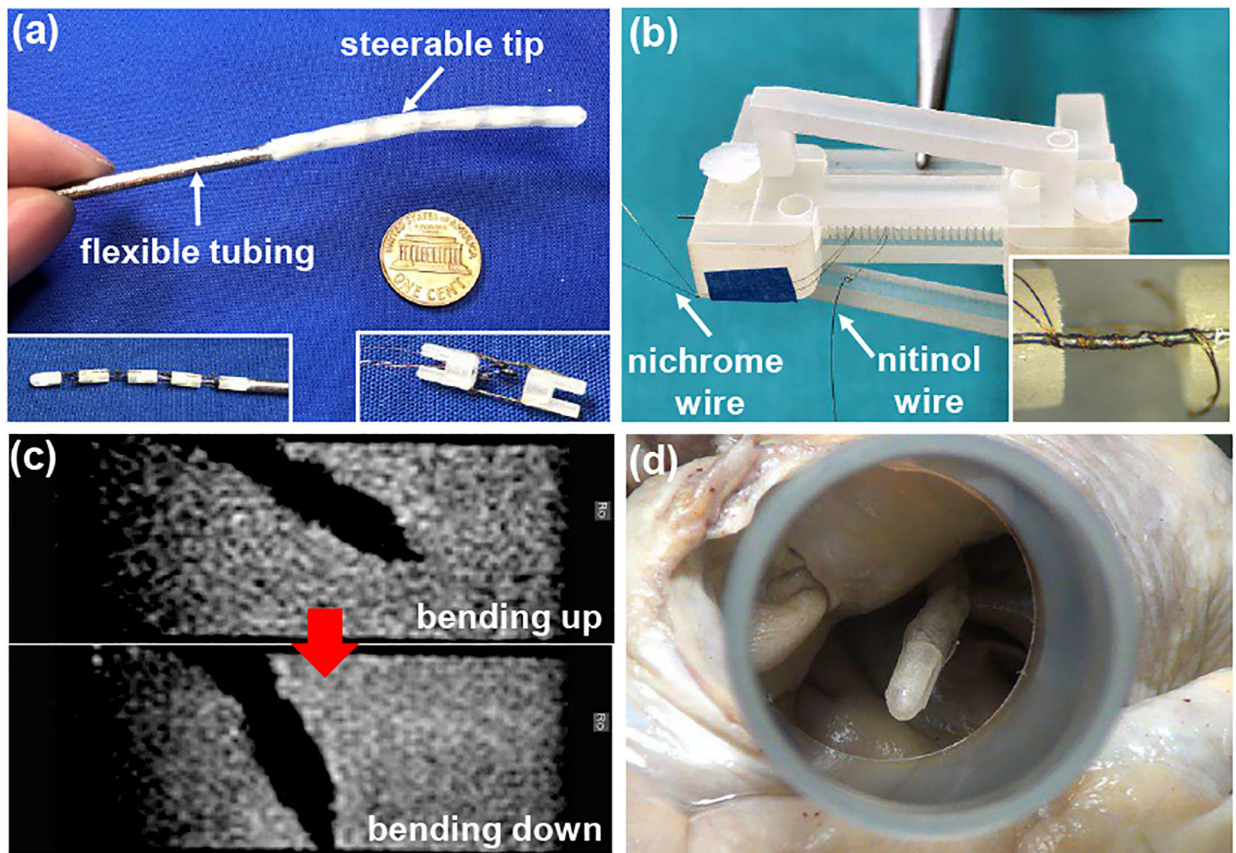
Development and evaluation of the robotic catheter for AFib treatment: (a) prototype of the robotic catheter, (b) routing nichrome coils around the SMA wire, (c) manipulation of the catheter tip under MR imaging guidance, and (d) *ex vivo* demonstration of the catheter using an explanted human heart.
